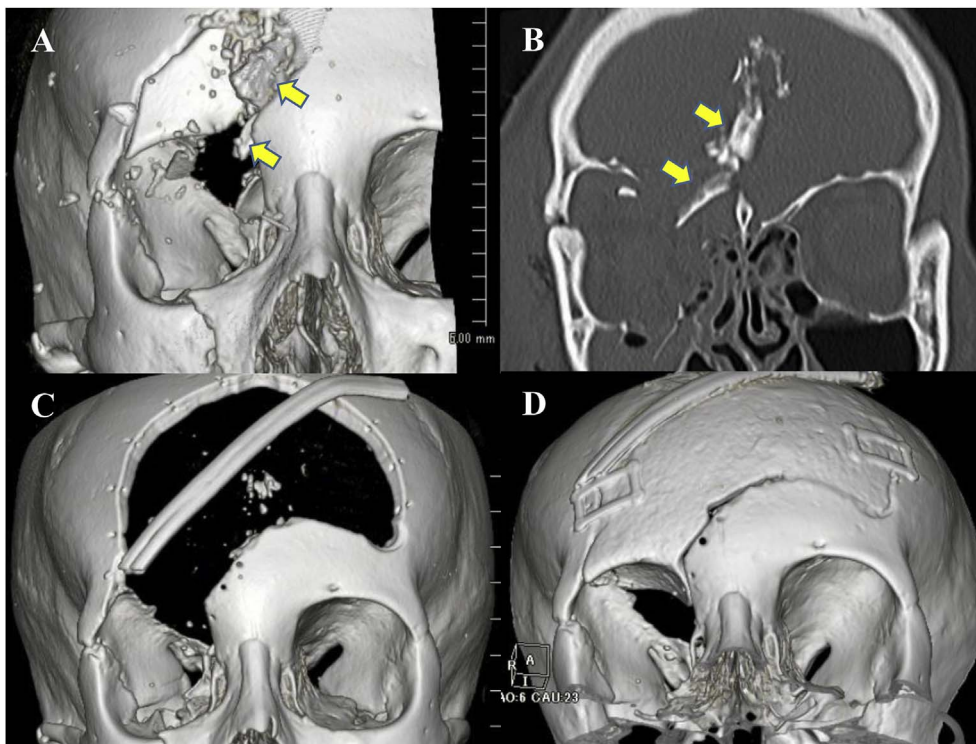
Injury of the skull base assessed by computed tomography. (A, B) A shard of glass (arrows) getting stuck in the frontal through the right orbital roof. (C) After decompressive craniectomy. (D) Reconstructed orbital roof with an artificial bone.
